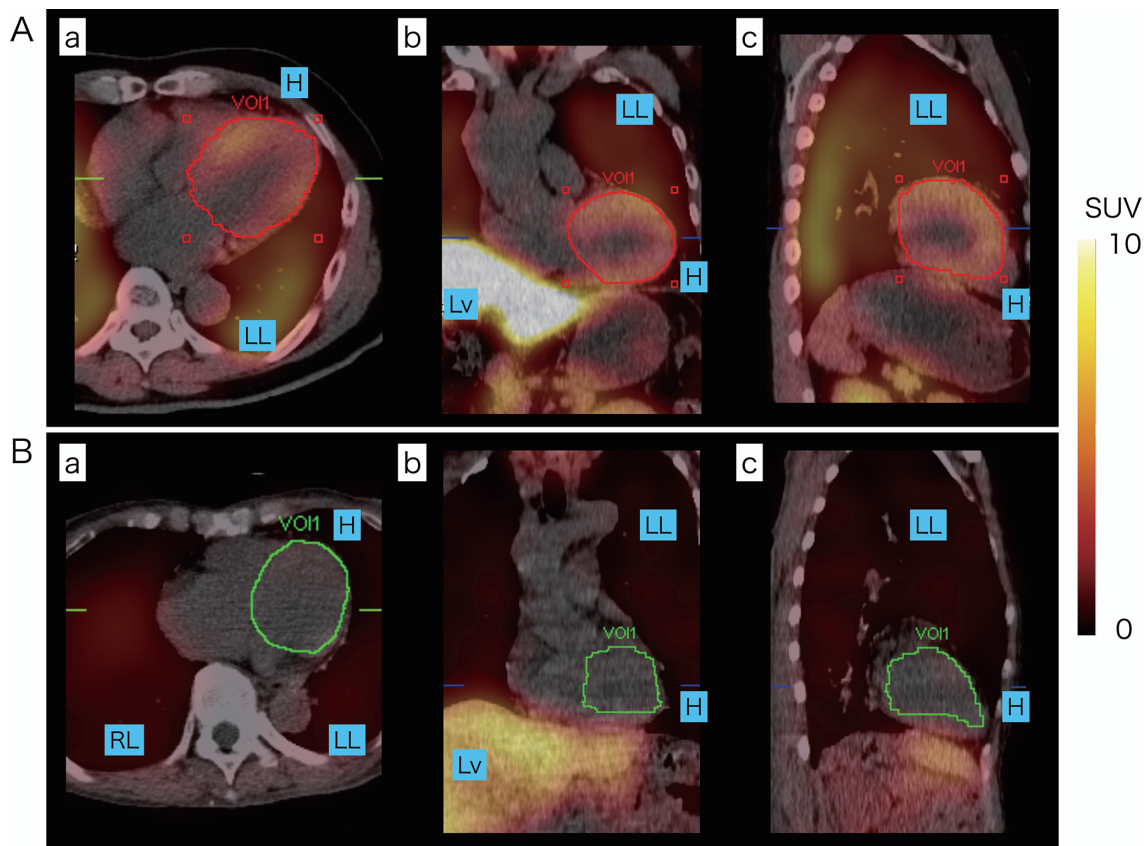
Manual three-dimensional left ventricular segmentation images with ^{123}I -MIBG SPECT/CT data.
